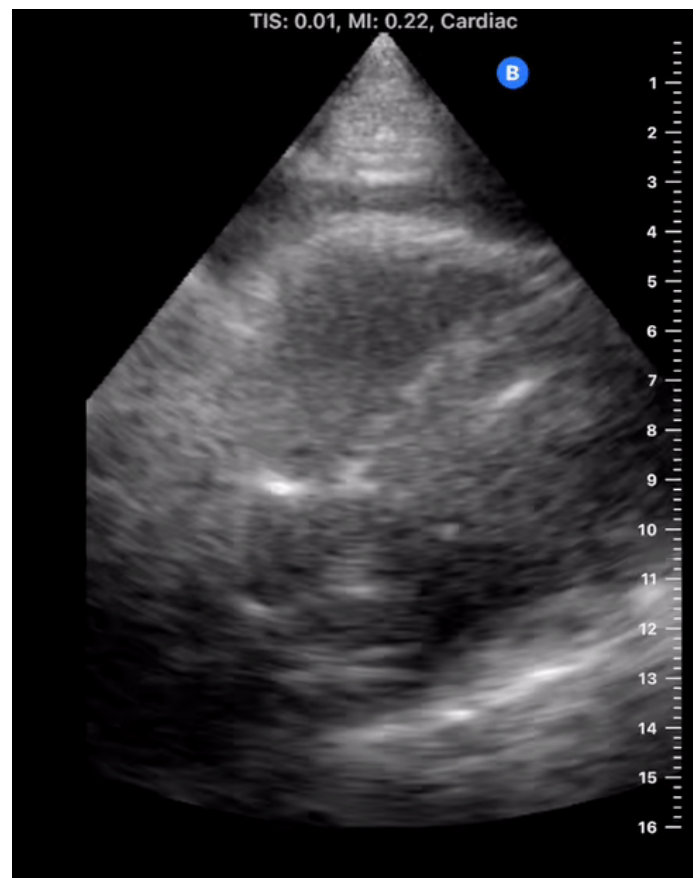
ECHOCARDIOGRAPHY OF PERICARDIAL EFFUSION SECONDARY TO ACUTE PERICARDITIS.
